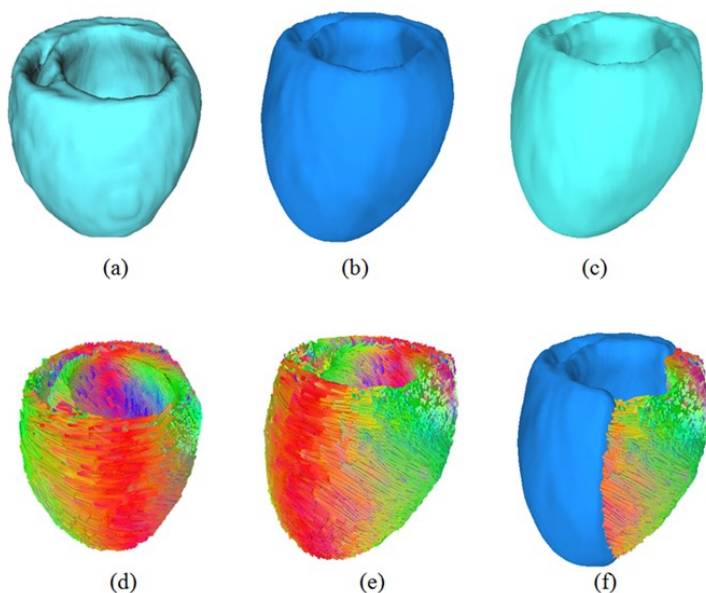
Mapping cardiac fiber orientations to the ultrasound volume based on the deformation field of both ultrasound and MRI volumes.
